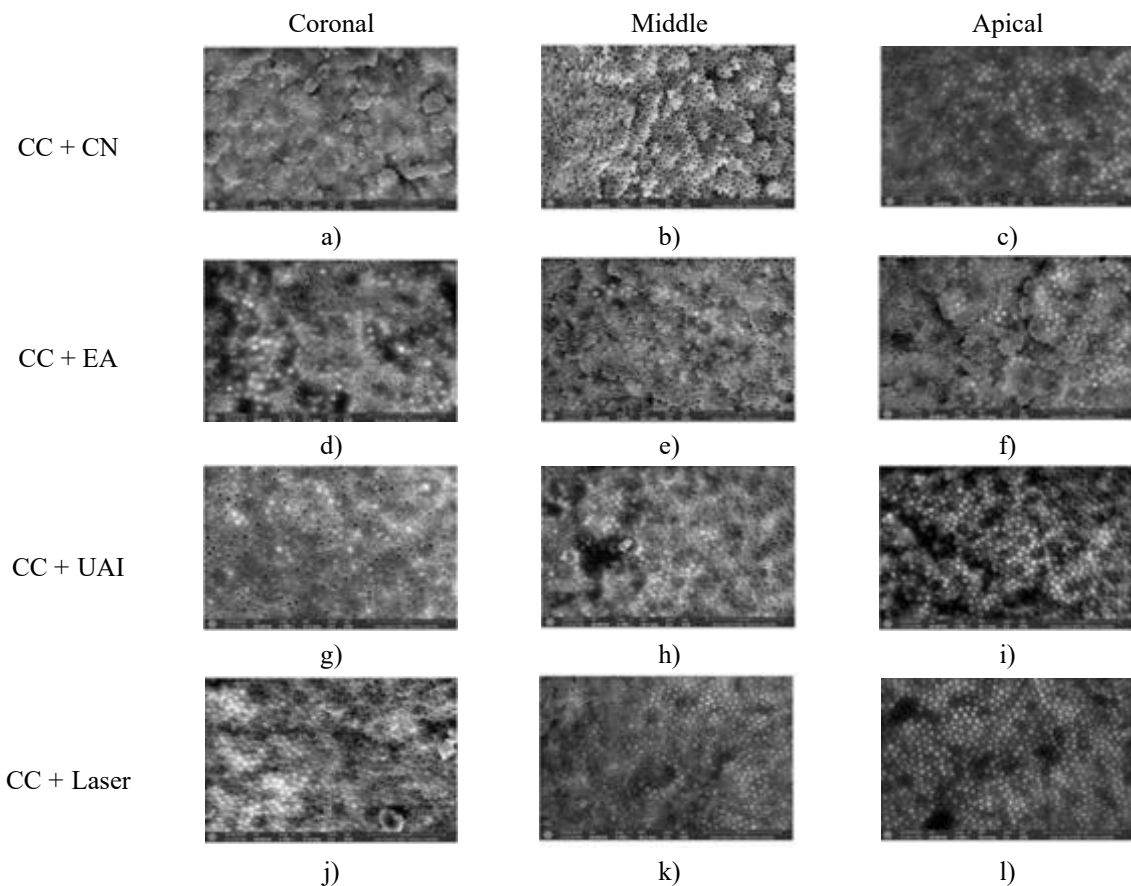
Representative SEM images (magnification 2500×) showing root canal lumen at coronal, middle, and apical sections using CC (continuous chelation) + CN (Conventional needle irrigation, EA (EndoActivator), UAI (Ultrasonic activated irrigation), and Er:Cr:YSGG laser.
